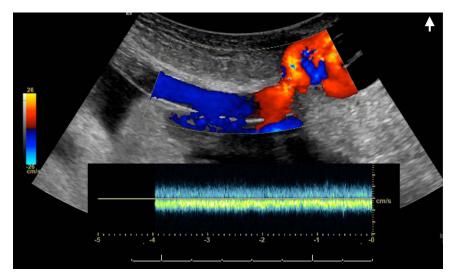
Doppler image demonstrating hepatofugal, nonphasic blood flow at 72 cm/s within the hernia sac.
